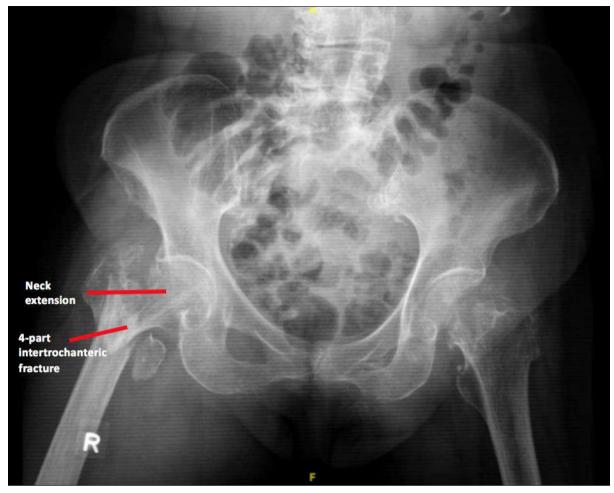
Pre-operative X-ray of antero-posterior view of pelvis showing a concomitant right sub-capital neck of femur fracture and four-part intertrochanteric fracture
